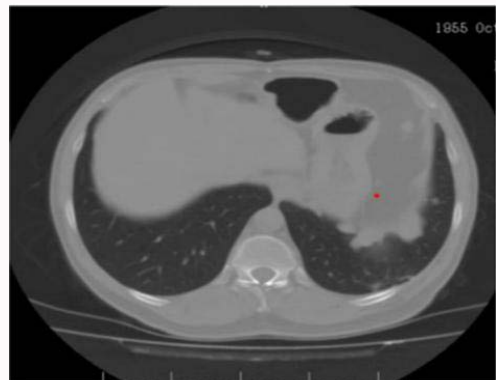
Computed tomography of the thorax showing similar lesions on the diaphragmatic surface.
